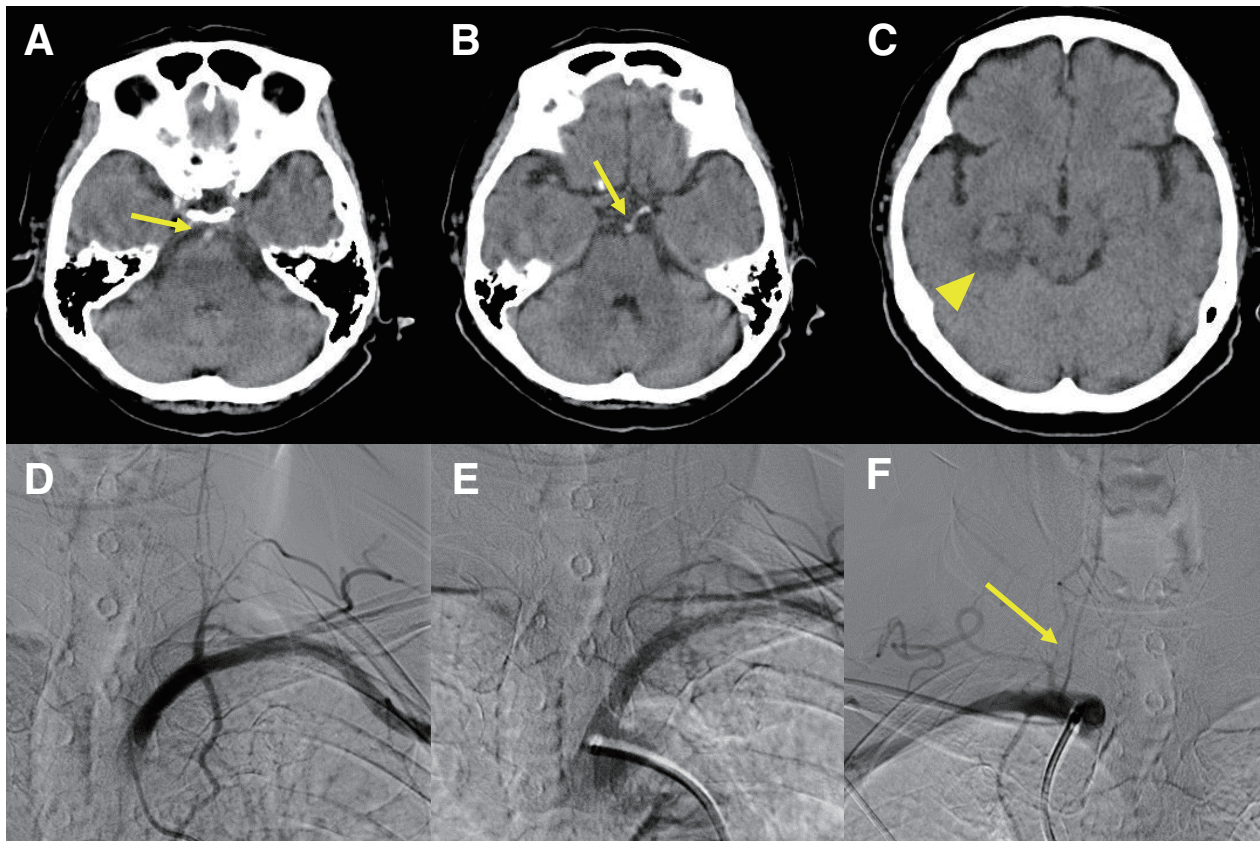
(A–C) Preoperative head CT revealed early ischemic changes in the right parahippocampal gyrus (arrowhead) without intracranial hemorrhage and showed the hyperdense vessel sign in the BA and the left posterior cerebral artery (arrows). (D and E) Preoperative left
